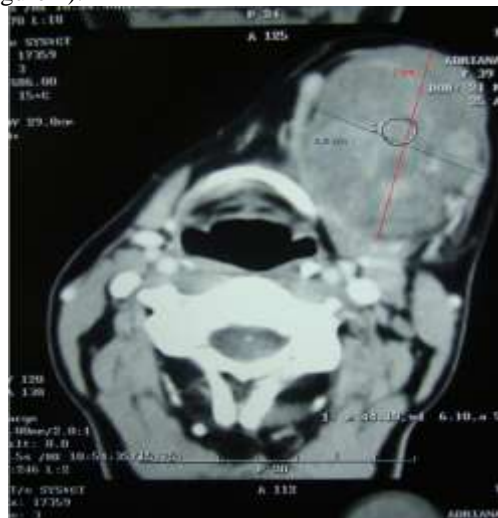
Computed tomography. Axial cut. Source: the author
